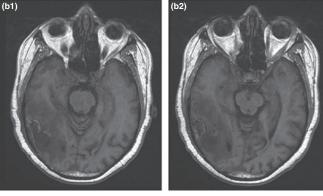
Cerebral T1-weighted MRI: axial sequence at the level of cerebral trunk (just above the pavilions of ears). Panel a: presurgical MRI: right perilesional oedema with right ventricular narrowing and partially necrosed temporoparietal tumour mass with thickened wall, invading meningeal structures (high gadolinium enhancement sequence). Panels b1 and b2: sixteenth postsurgical day MRI: right temporoparietal collapsed postsurgical virtual cavity with slight thickened meningeal structures (increased T1 MRI signal), residual perilesional oedema and right ventricular narrowing.
